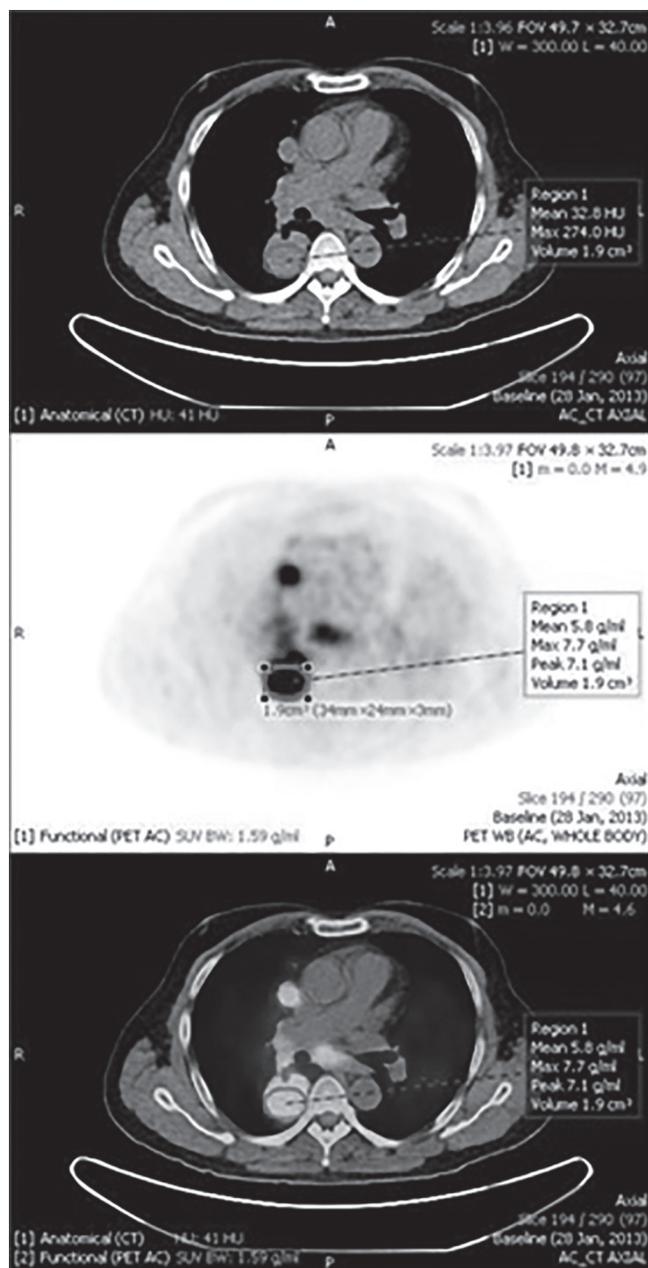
PET-CT images at presentation (January 2013). Metabolically active mass lesion in right lower lobe abutting the right paravertebral costal pleura.
